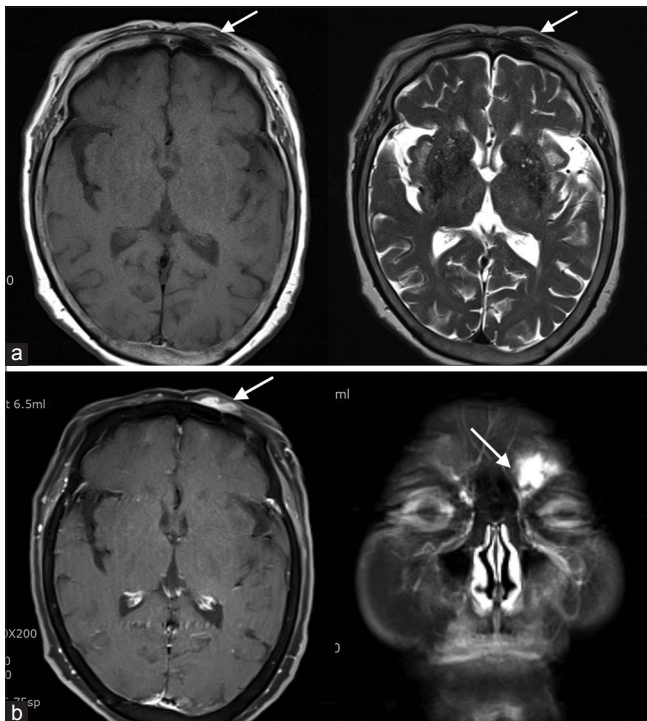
Magnetic resonance imaging findings of the lesion. (a) T1-weighted (left) and T2-weighted axial (right) images showing a poorly-margined, isointense signal mass (arrows) with inner high signal area possibly indicating hemorrhage or thrombosis, and dilated or serpiginous vascular structure compatible with abnormal veins. (b) T1-weighted axial (left) and coronal (right) images showing the location of lesion (arrows) with strong enhancement
